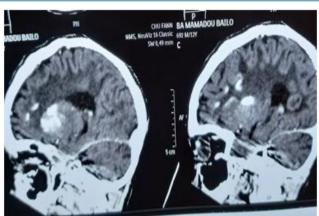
Brain CT, axial slice, upper and sub-tentorial stage and a parenchymal window
